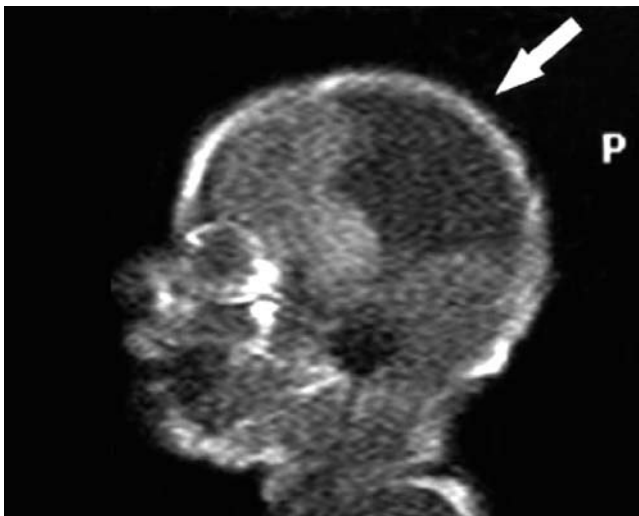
A wide CSF cleft is seen occupying the parietal lobe (arrow) in the T1 weighted sagittal MRI image.
